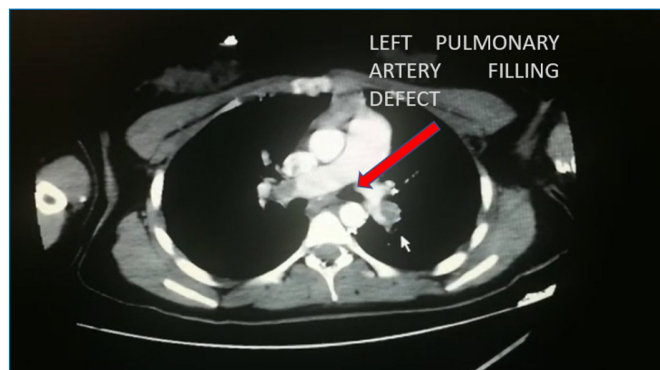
Left pulmonary artery filling defect in computed tomography pulmoner angiogram.
